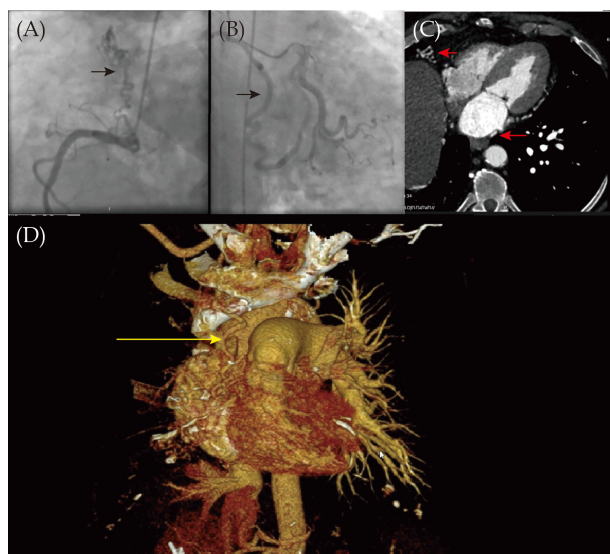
Coronary angiography and computed tomography. (A): Collaterals from right coronary artery; (B): collaterals from circumflex artery; (C): image of collaterals in computed tomography (red arrow); and (D): image of dense collateral networks in coronary computed tomography angiography (yellow arrow).
